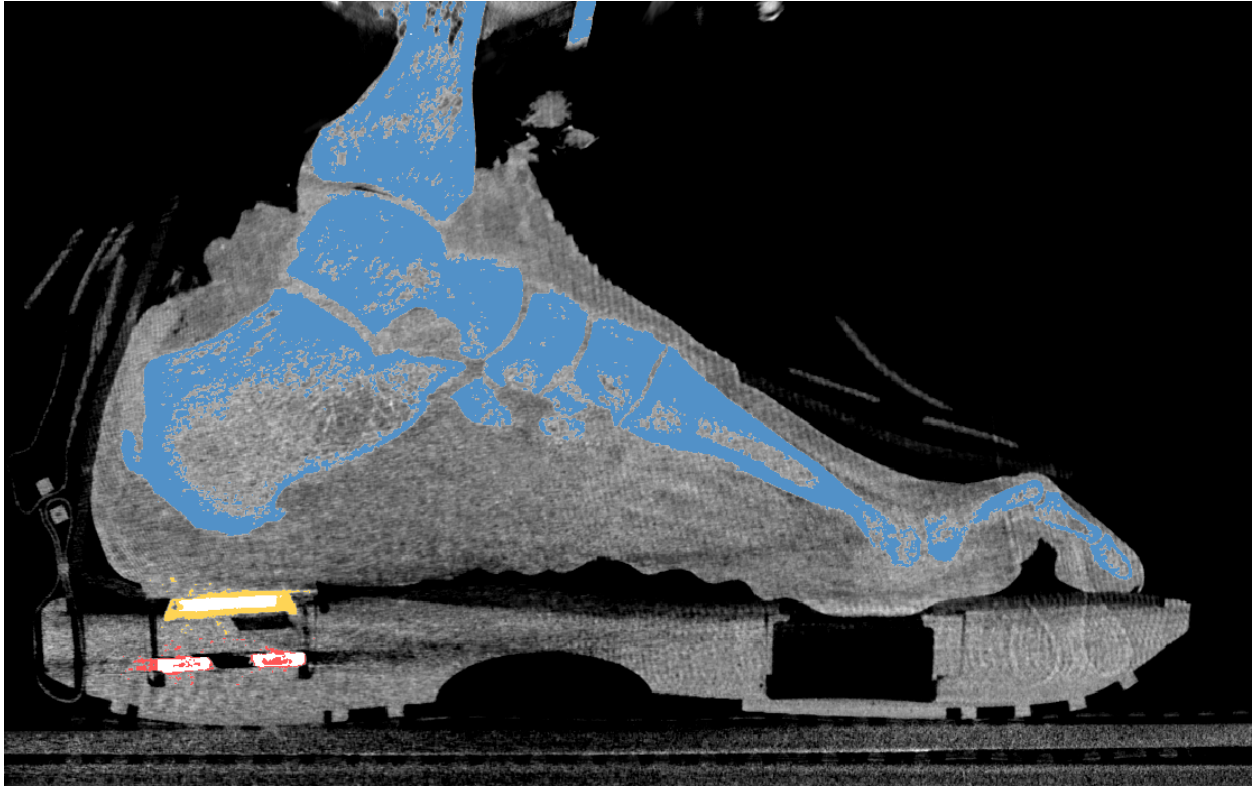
CT image of a cadaveric foot inside the Ultrashoe. The bones in the foot (blue), the ultrasound probe (yellow), and the load cells (red) are highlighted. The edge of the gel pad can be partially discerned at the lower left edge near the probe, but it is hard to distinguish from tissue in the area of contact with the probe.
